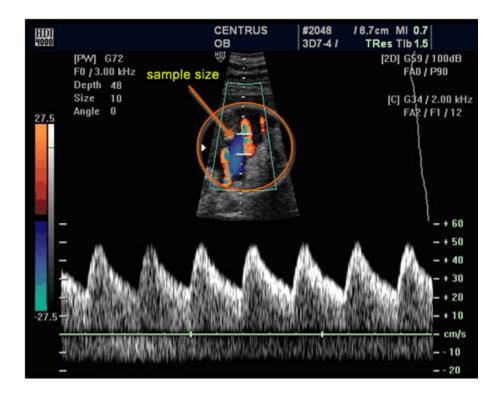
Influence of gate size. The spectral Doppler gate insonates an artery and vein and the sonogram shows flow from both of these vessels. The calculation of mean velocity (arrow) is meaningless since velocities from one vessel subtract from those of the other
